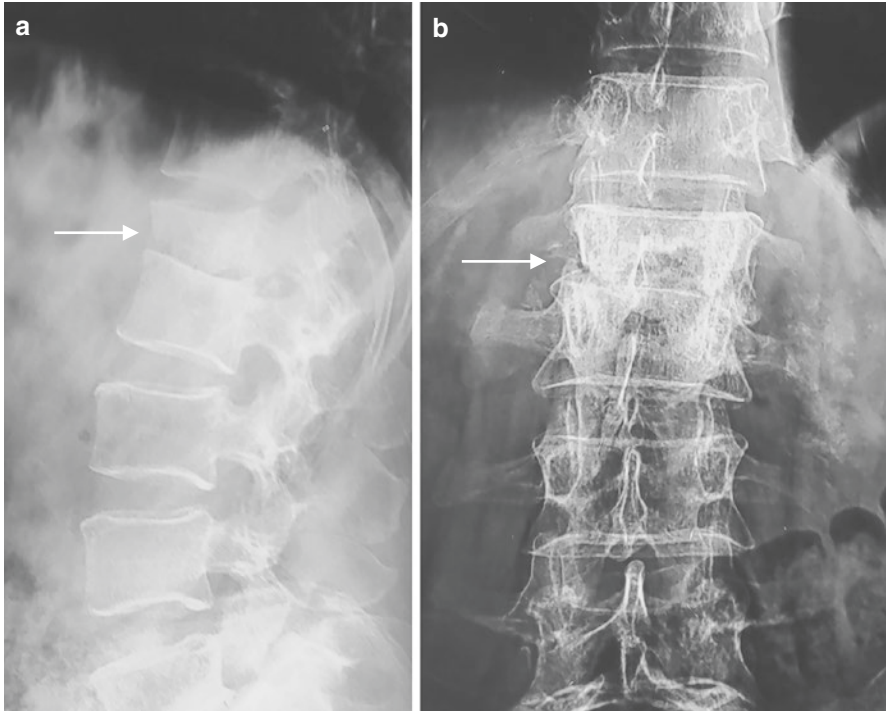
Radiograph lateral (a) and AP (b) view reveal loss of intervertebral disc space associated with destruction of the anteroinferior aspect of L1 vertebral body (arrow)—*marginal variety of caries*
